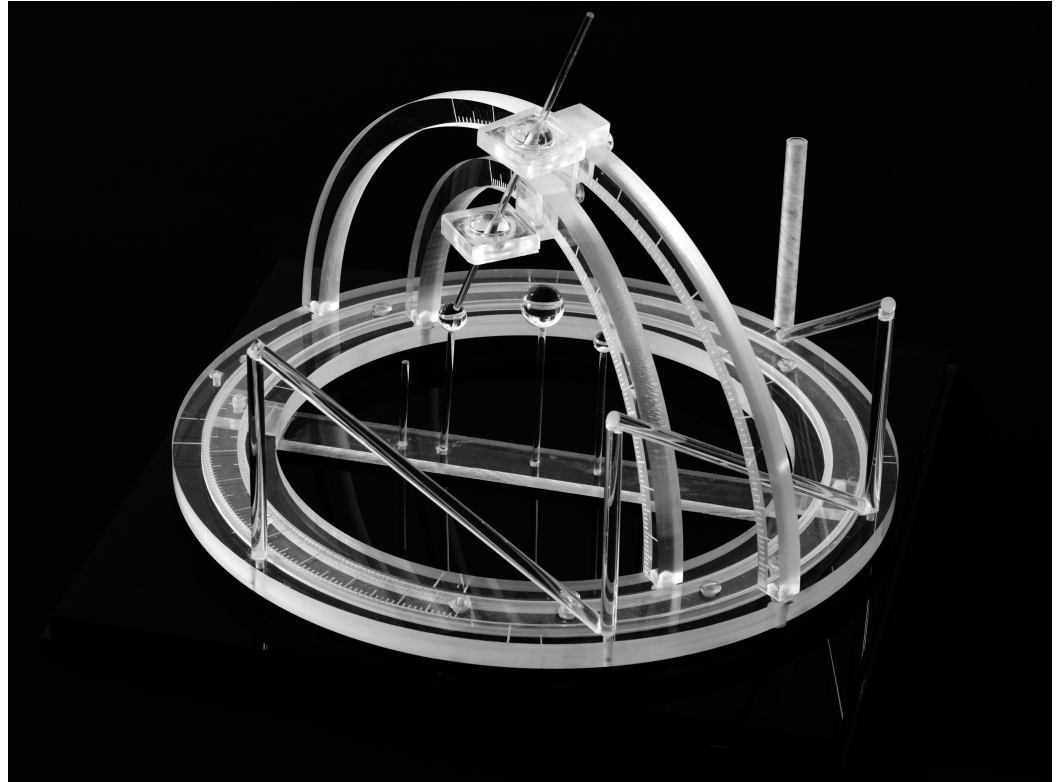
The First CT-Compatible Stereotactic Frame
